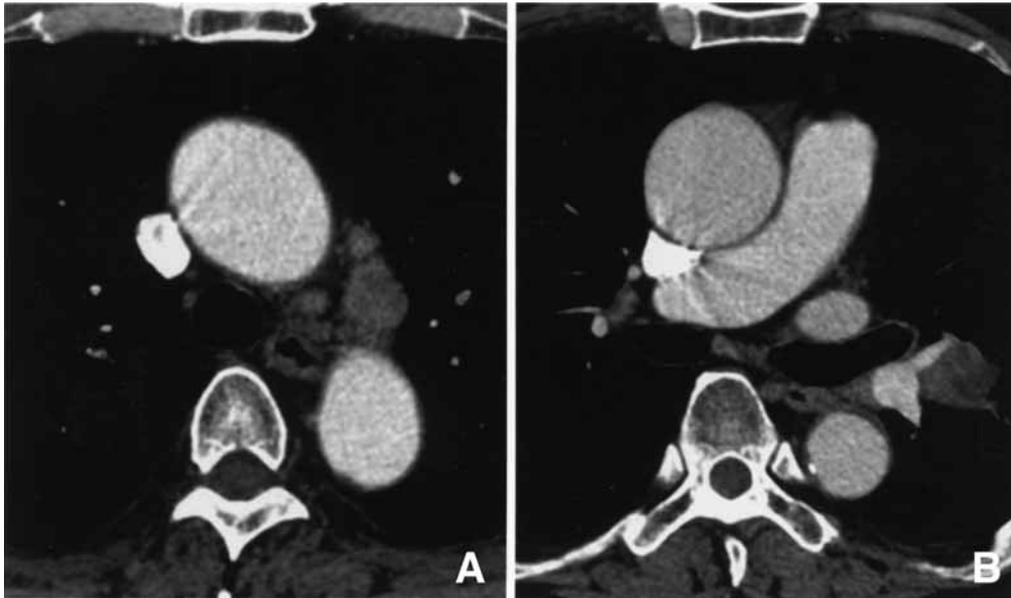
Contrast-enhanced computed tomography (CT) scans of case 1 showing left hilar and mediastinal lymphadenopathy (A, B).
